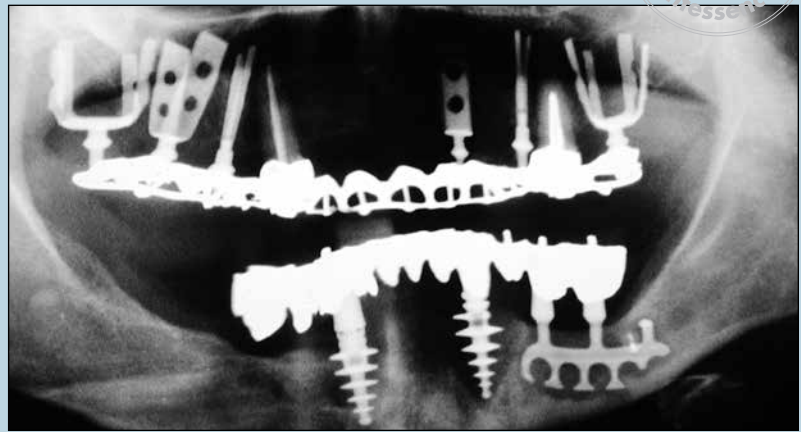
This complete mandibular fixed prosthesis failed 10 years after loading. (a to d) Note how the bone loss involved the entire length of both the teeth and the implants. (e to g) Panoramic radiographs taken during the treatment phases and at the 5-year follow-up. (Clinical case in collaboration with Dr Alessandra Carrera, Galbiate, Italy.)
